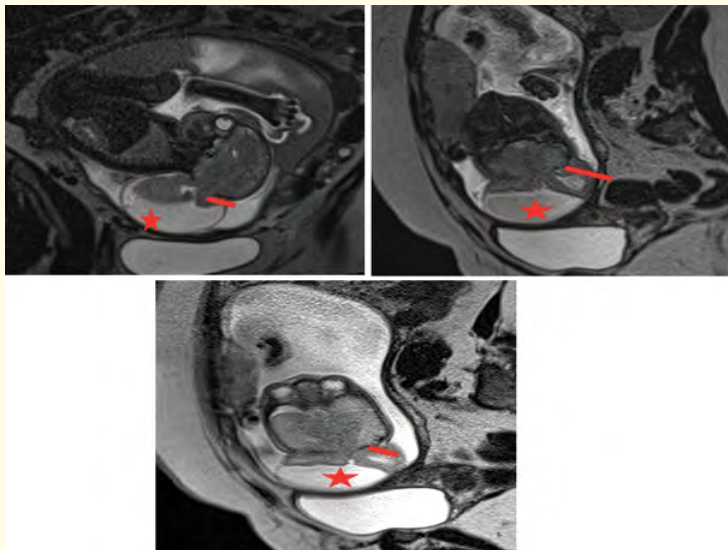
Coronal, axial, and sagittal fetal MRI images show a midline occipital calvarial defect (arrows) with herniation of brain parenchyma and CSF forming a sac-consistent with an occipital encephalocele. In addition, the cerebral surface appears abnormally smooth for gestational age, with absent expected primary sulcation, compatible with lissencephaly.
